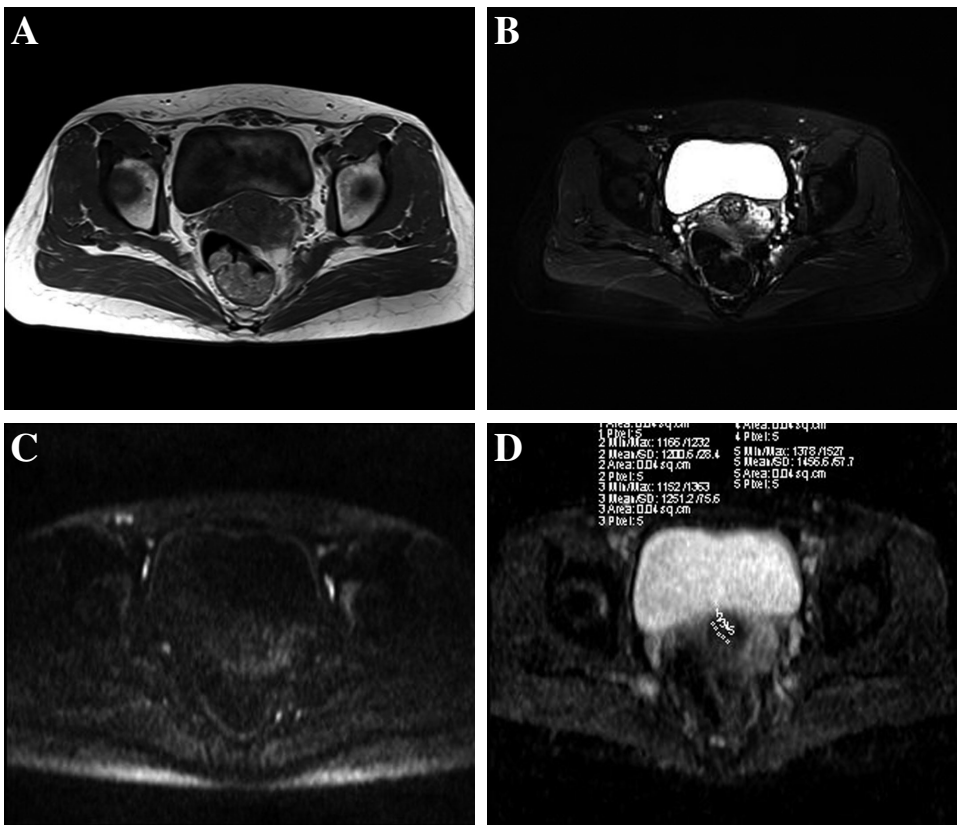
MRI and ADC features in the patients with negative surgical margin after LEEP. A: T1-weighted image shows homogeneous slightly hypointensity in cervical tissue. B: Fat-suppression/T2-weighted image shows the four structures in cervix; the surgical margin presented a hyperintensity which indicated inflammation and edema. C: DWI image shows the four structures in the cervix; the hydropic margin has a hyperintensity. D: In the ADC map, the ROIs were measured five times along the surgical margin of cervix, the mean value of ADC was $1.225 \times 10^{-3} \text{ mm}^2/\text{S}$.
